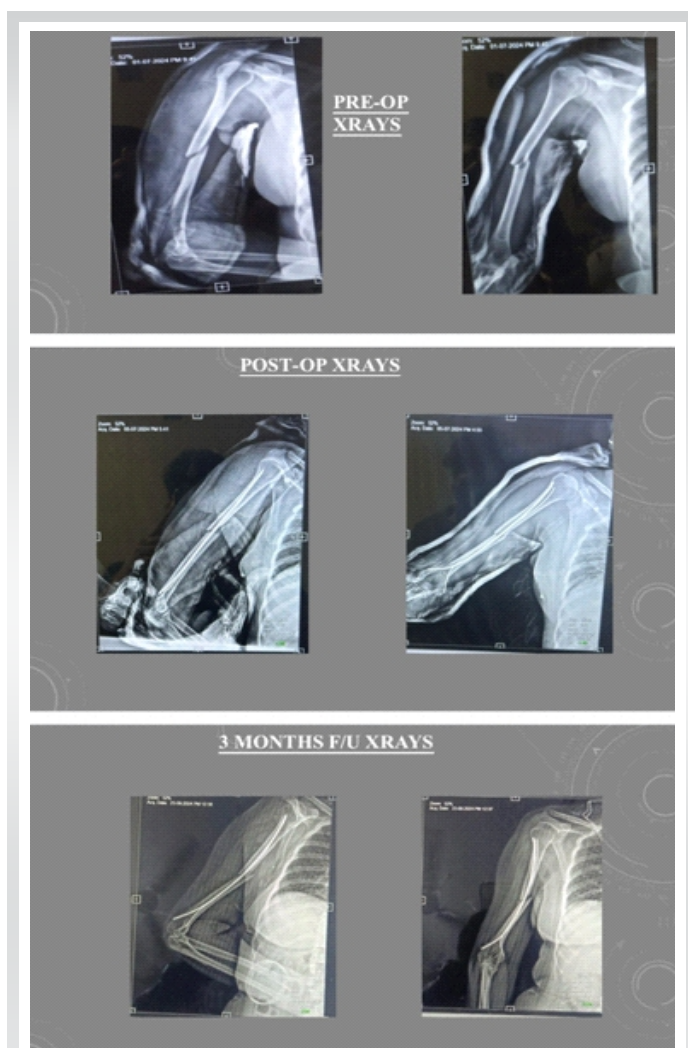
(a and b) Pre-operative and post-operative radiographs – Case 4.
